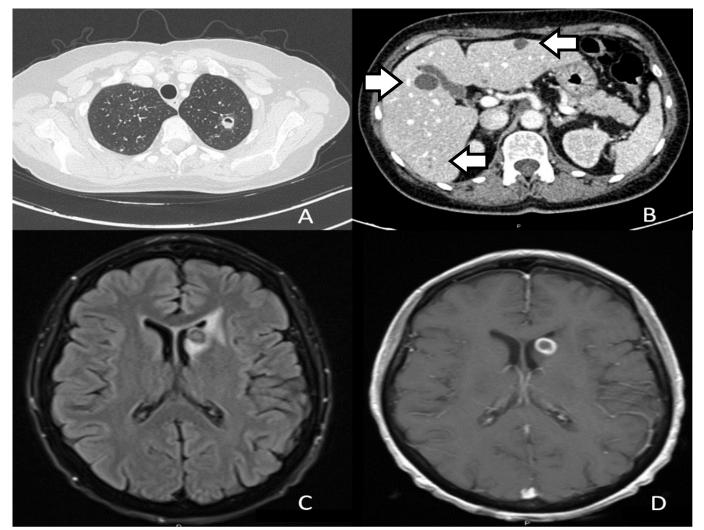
A) CT scan. In the left lung is present a 20 mm excavation filled with fluid: air-crescent sign. B) CT scan of the abdomen. Two hypodensae cystic hepatic lesions of 2 and 1.5 cm; other millimetric lesions can be seen (white arrows). C) Brain MRI: T2 weighted sequence. An 11 mm cystic lesion is present in the left head of the caudate nucleus, with compression of the left lateral ventricle. Mild perilesional edema is present. D) Brain MRI: T1 weighted gadolinium contrast-enhanced sequences. The same cystic lesion showing a concentric rim of contrast.
